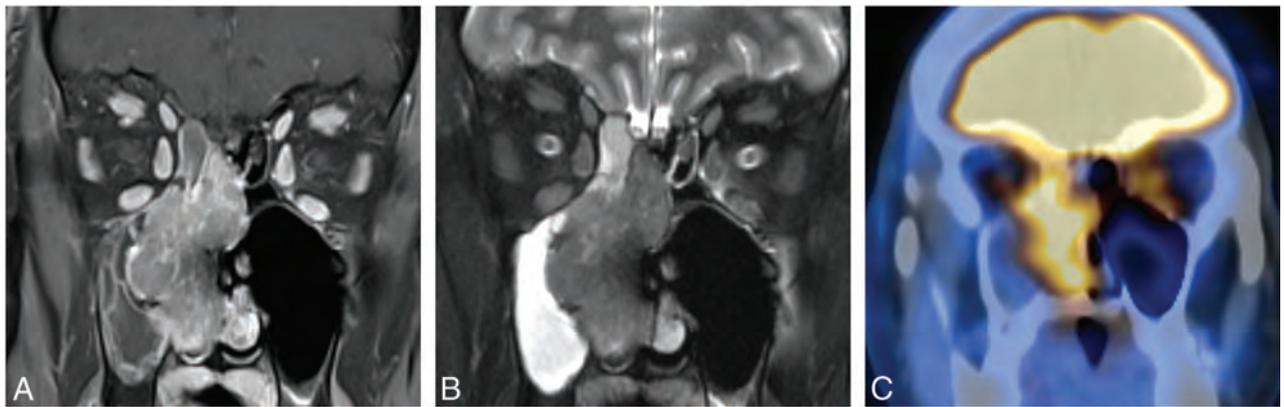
Patient 2. A, Coronal enhanced and fat-suppressed T1WI shows avid heterogeneous enhancement in right nasal cavity mass. There is no intracranial or orbital extension, and this mass was characterized as expansile. B, On this coronal STIR image, the mass is approximately isointense to cerebral cortex and can be distinguished from obstructive secretions in the adjacent ethmoid and maxillary sinuses. C, Coronal fused image from PET/CT examination demonstrates avid uptake in the right nasal cavity mass.
